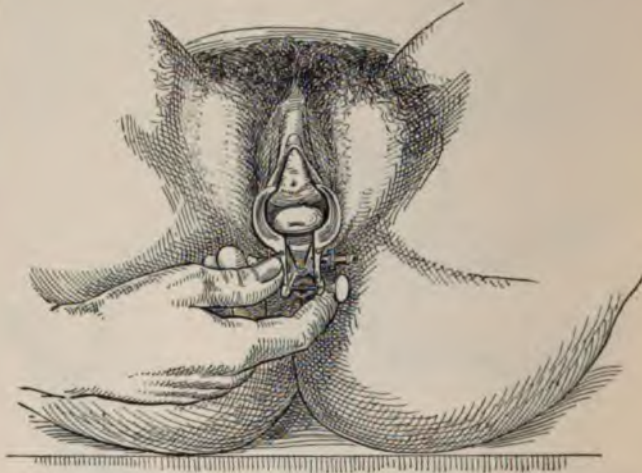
INDIRECT INSPECTION OF THE VAGINA (page 235).
